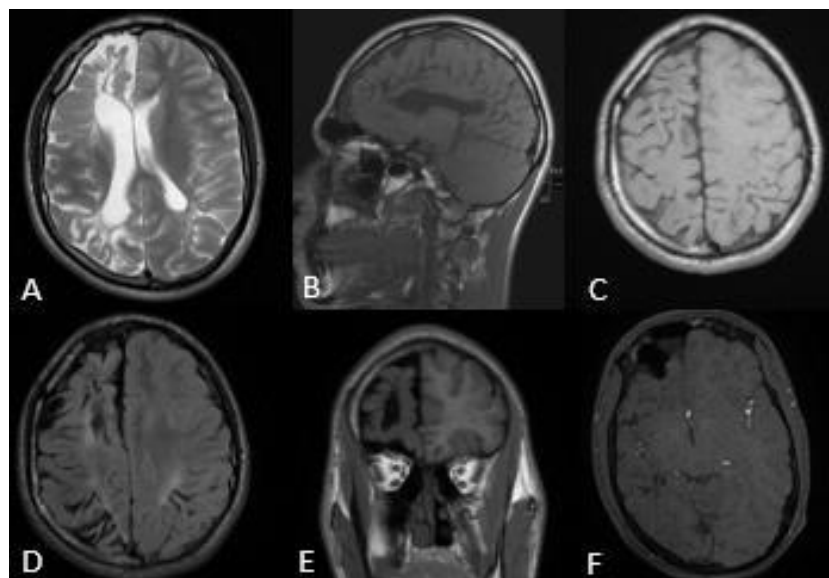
Brain MRI – Axial T2 sequences (A), sagittal T1 (B), axial T1 (C), axial T2 FLAIR (D), coronal T1 FLAIR (E), and TOF FS (F)
